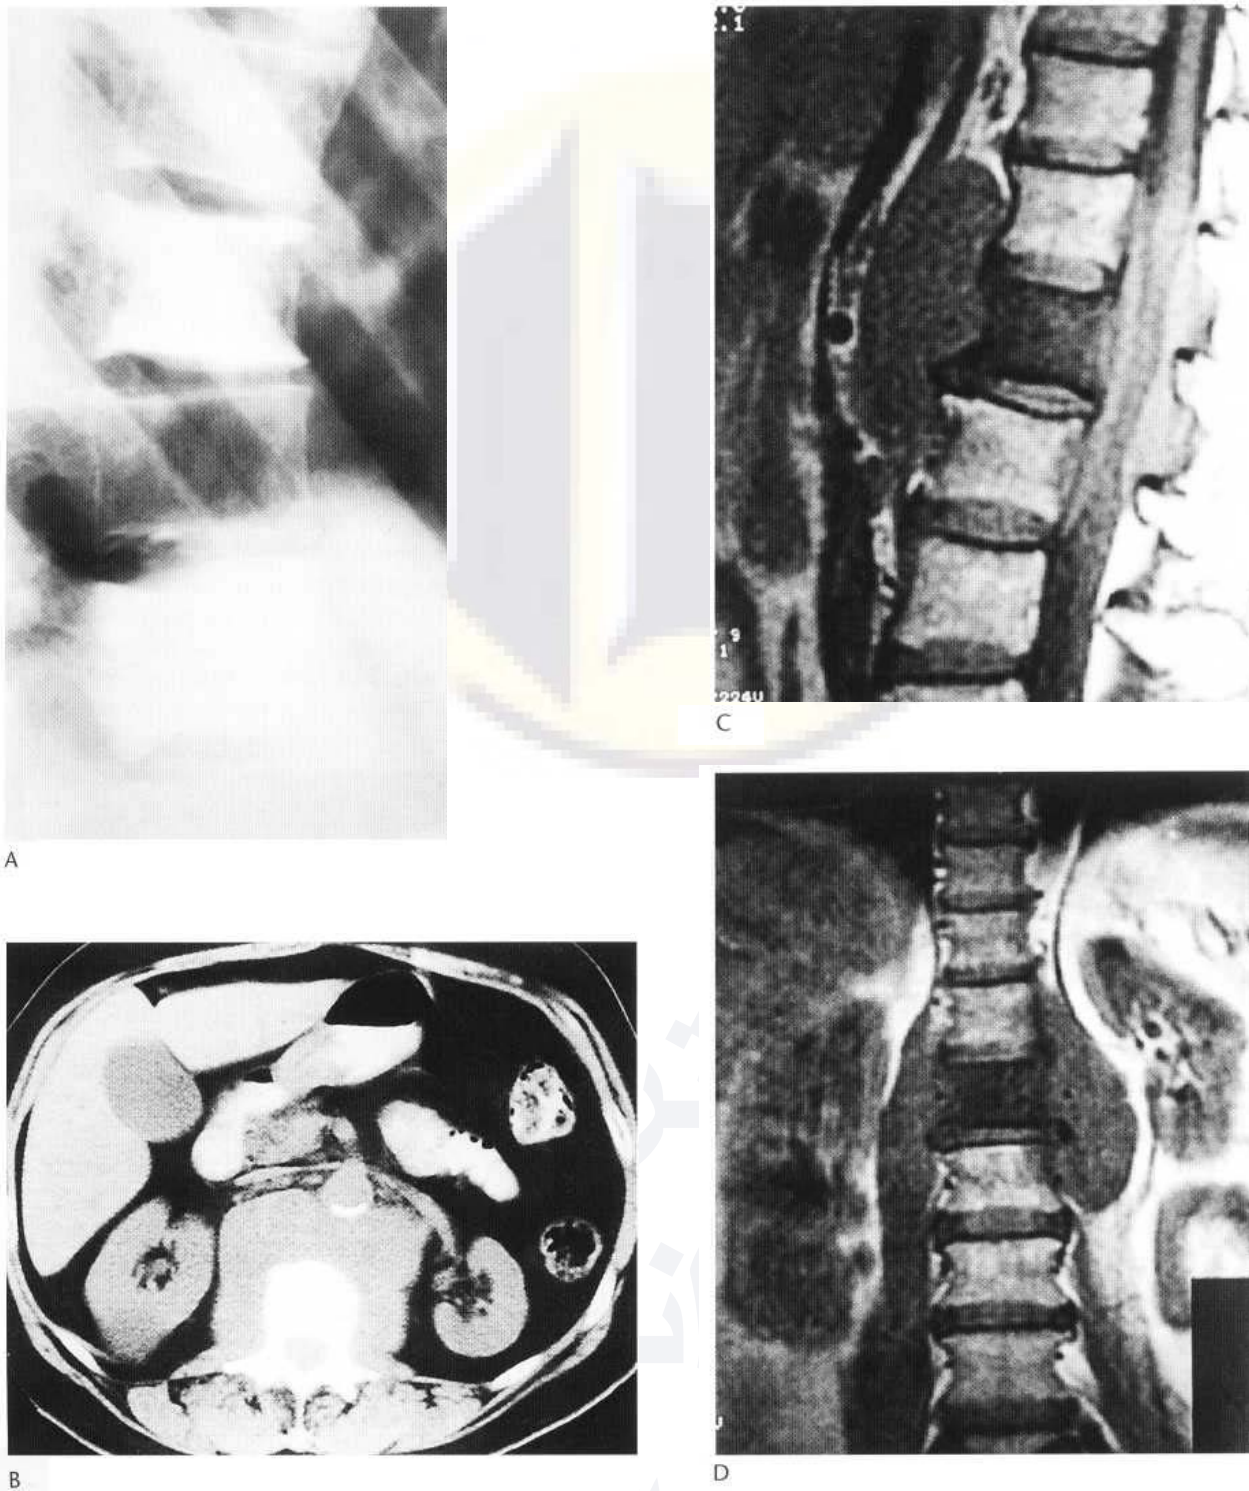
Hodgkin's disease. (A) The common pattern of endosteal sclerosis and patchy bone destruction is shown in the vertebral body of T9 in an adult man. Similar changes are also present at T1. These features are virtually diagnostic. (B) In another patient, an intravenous enhanced CT section of the abdomen demonstrates a densely sclerotic lumbar vertebral body associated with a large paravertebral soft-tissue mass. Sagittal (C) and coronal (D) T₁-weighted images show low signal intensity within the upper lumbar vertebral body due to diffuse sclerosis and the extent of the soft-tissue mass. This extends into the central spinal canal and circumferentially around the thecal sac.
